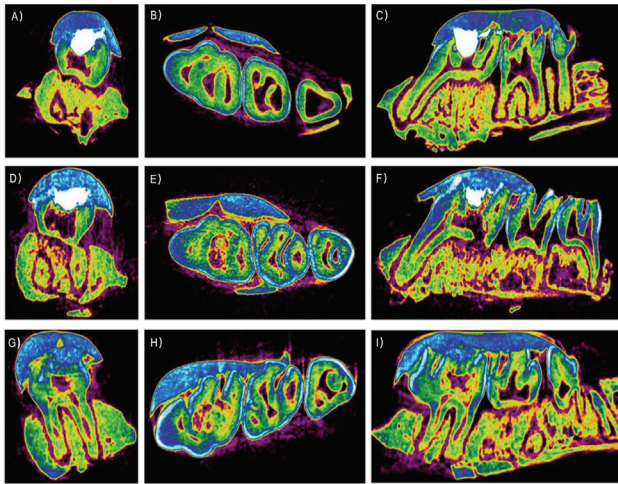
Micro CT images after 2 weeks of pulpotomy. (A-C) Pulpotomy with FC, (D-F) Pulpotomy with MTA, (G-I) Pulpotomy with TheraCal LC. (A, D, G) B-L sagittal view, (B, E, H) coronal view, (C, F, I) M-D sagittal view. Blue and white (pulpotomy agent or restorative materials), purple (pulp space), green (dentin).
